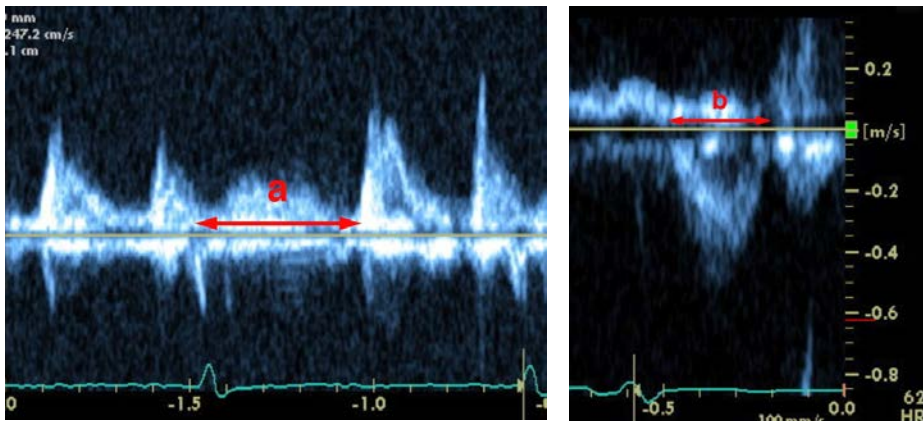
Calculating the RV Myocardial Performance Index (MPI) by spectral Doppler. MPI is the ratio of the sum of the isovolumic contraction and relaxation times (IVCT+IVRT) divided by the right ventricular ejection time (RVET (b)) and is calculated by the equation $MPI = (a-b)/b$.
